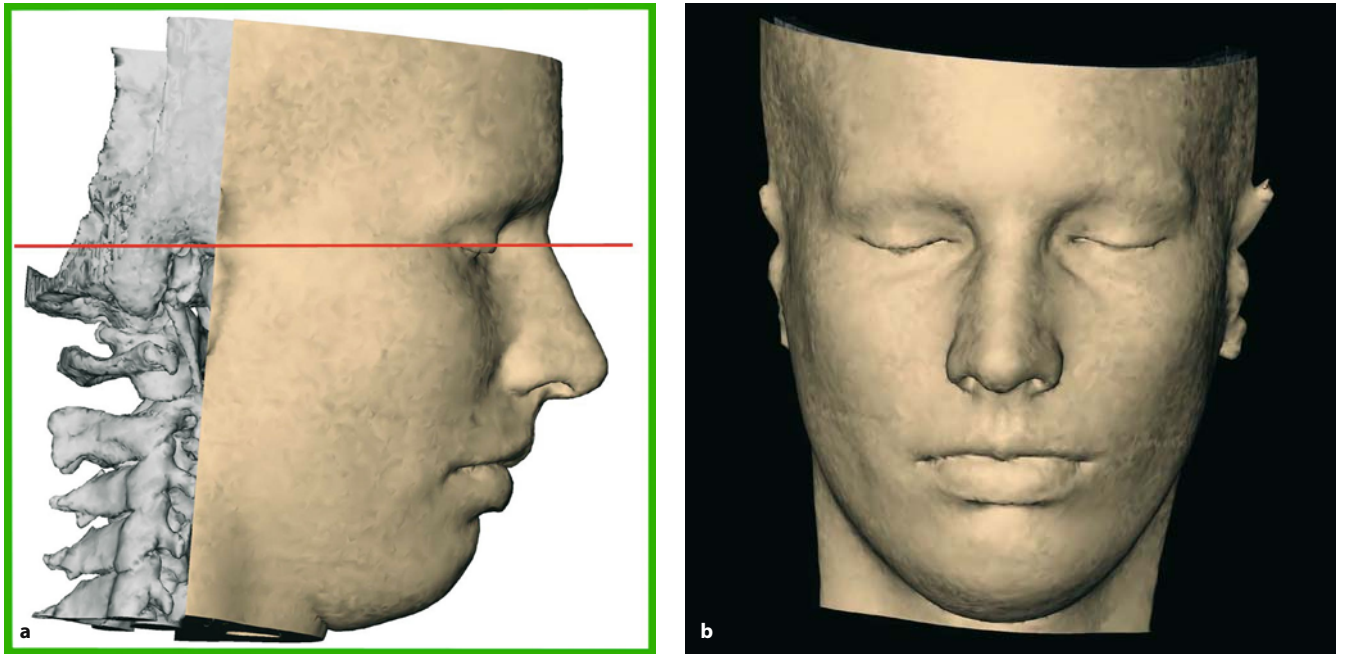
a,b. Frontal view (patient K.C.). In order to compute the virtual frontal X-ray, the skull is virtually positioned in the frontal view with the cantho-meatal or trago-canthal line parallel to the horizontal plane
